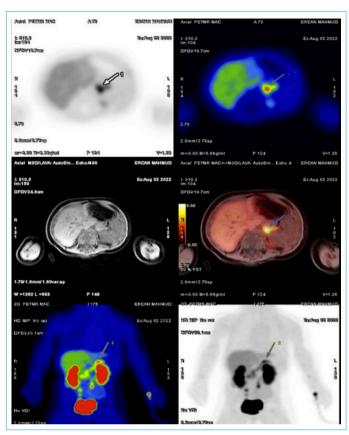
18F-DOPA-PET/CT scan of a focal lesion in the tail of the pancreas.
